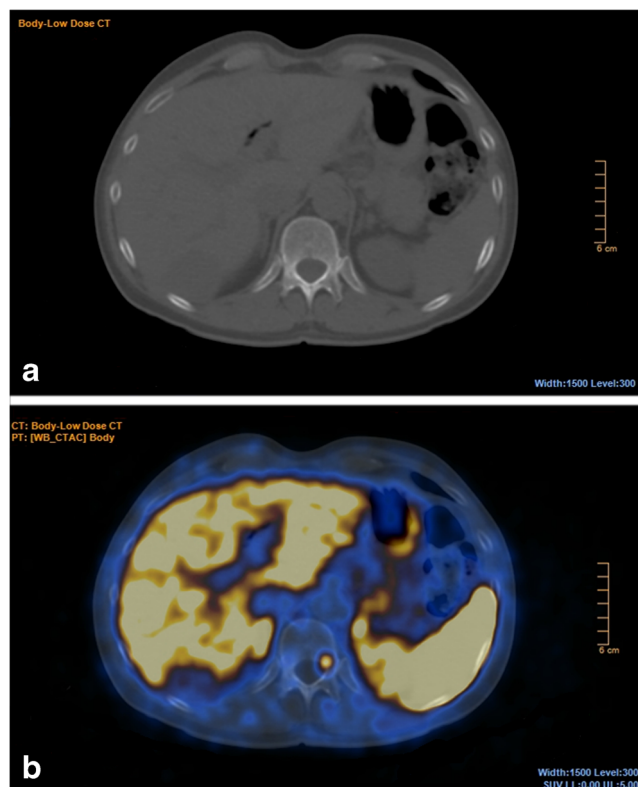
Axial CT and fusion images centred on a vertebral metastasis of T12 demonstrating an intense DOTA-TOC uptake ($SUV_{max}=6.5$, SUV_{max} ratio to reference vertebra=5.6, to liver=0.92, to spleen=0.22) but without a corresponding lesion on CT, in a 58-year-old man referred for recurrence workup of a pancreatic neuroendocrine tumour (NET)
